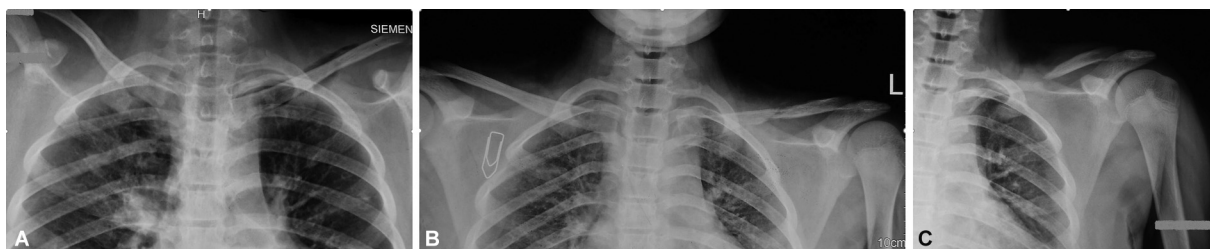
(A) Plain radiograph taken in medical intensive care unit did not reveal obvious bony abnormality. (B) Plain radiograph (taken 2 months later) showing areas of lysis in the middle third of left clavicle. (C) The radiograph (taken 2 months and 3 weeks later) revealed a pathological diaphyseal fracture with complete destruction of the middle third of left clavicle. There was also presence of surrounding osteopenia especially in the medial third clavicle.
